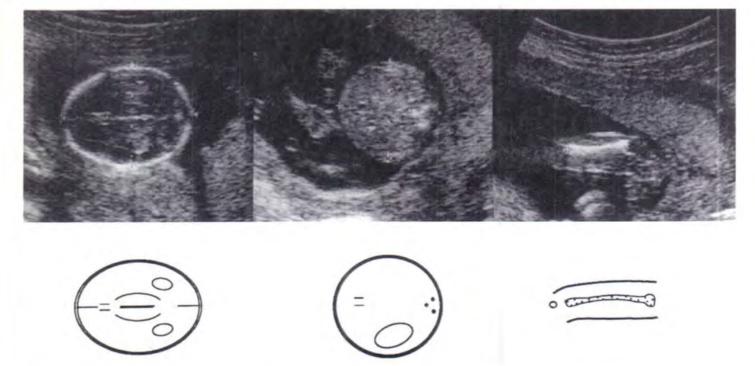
High-resolution, real-time ultrasound images of fetal head on left, the abdomen in middle, and femur on right in a 16-week fetus. Suitable images for age estimation.
